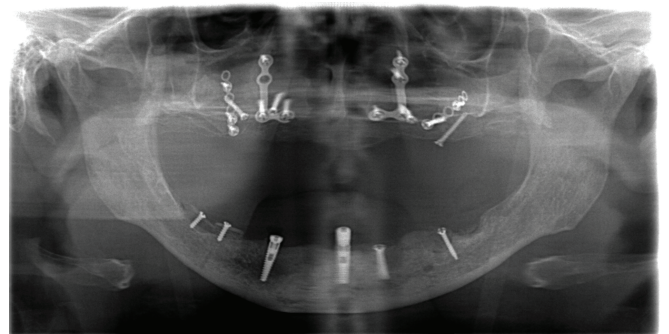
Early postoperative radiographic image after operation.
